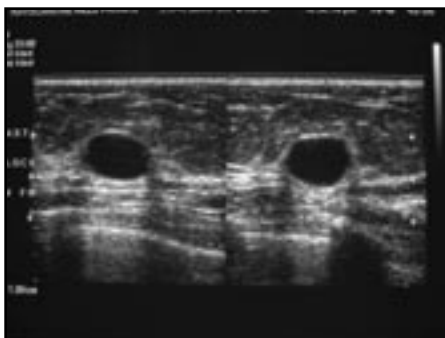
Simple cysts are characterised on ultrasound as: anechoic lesion (black hole); smooth, well defined borders and very thin capsule; posterior enhancement (transmission of ultrasound through fluid gives the appearance of enhancement or 'white' deep to the lesion)
